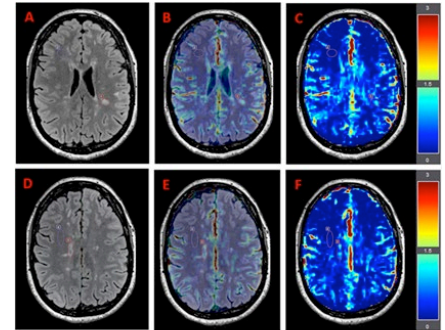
Two MS lesion ROIs (red) and two NAWM ROIs (violet) shown on FLAIR images (A&D) and on FLAIR with 50% APT<sub>w</sub> overlay (B&E) and corresponding APT<sub>w</sub> images (C&F) respectively of a 38 years-old female RRMS participant. Images (C&F) show higher APT<sub>w</sub> endogenous contrast in MS lesions ROIs comparing to NAWM.
